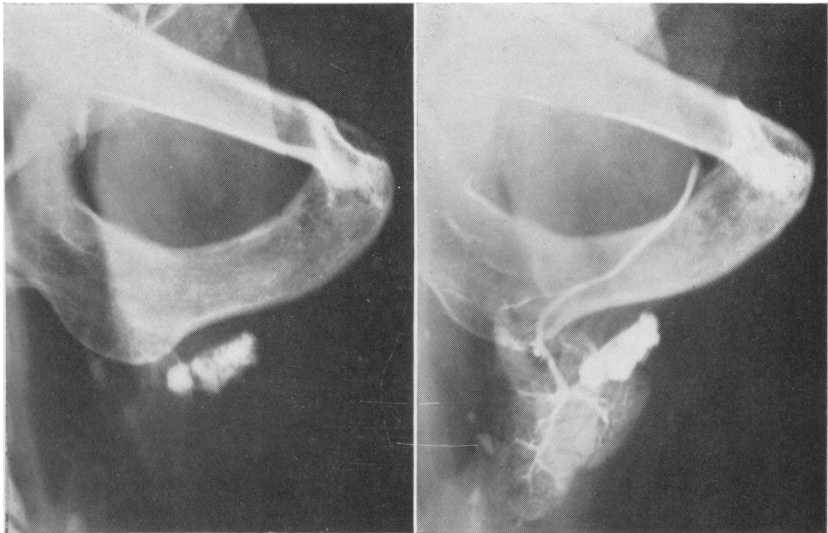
Comparative plain films and sialogram of a submandibular calculus.
